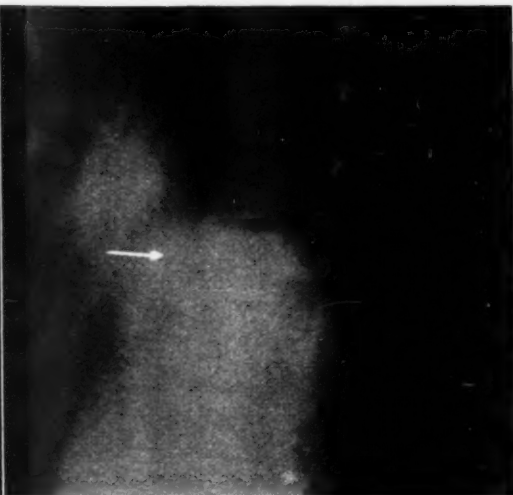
Case 2. X-ray five months after reduction.
